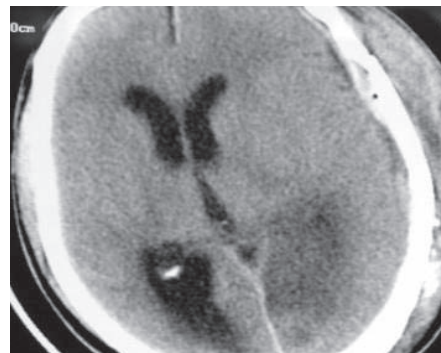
CT scan, 3 days after surgery showing complete resolution of SDH and presence of ipsilateral PCA infarct.
